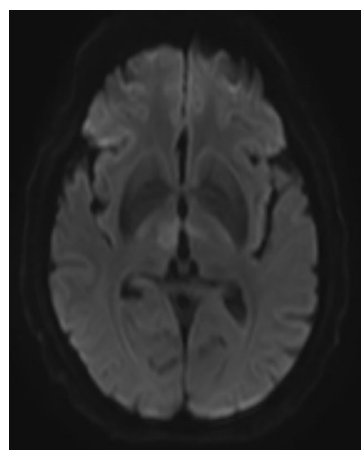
The T2-weighted image (T2WI) revealed a hyperintense signal indicating an area of acute infarction involving the bilateral thalamus region. The increased signal intensity on the T2WI is indicative of tissue edema and ischemia, consistent with an acute stroke. This hyperintensity clearly outlines the affected regions, providing a distinct visualization of the bilateral thalamic involvement.
